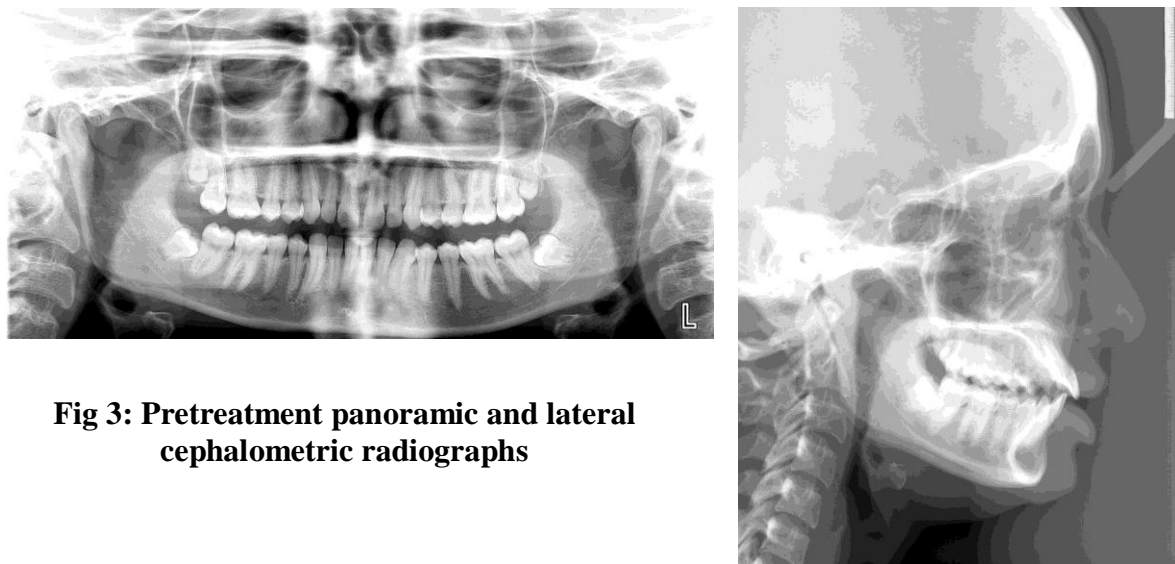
Pretreatment panoramic and lateral cephalometric radiographs
